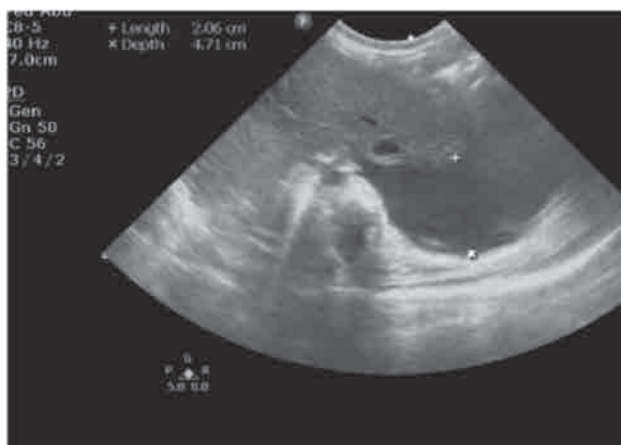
Ultrasound. Left pleural effusion
